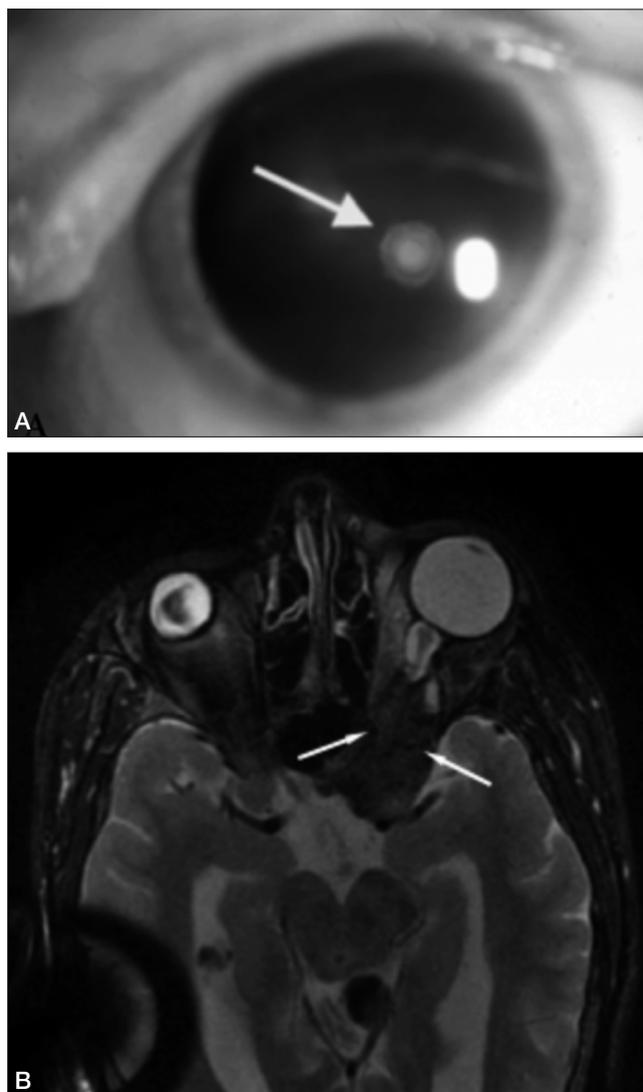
(A) Magnified view of the eye in an NF2 child showing subcapsular lens opacities (white arrow); and (B) Axial T2-weighted magnetic resonance image of the brain in a child with “congenital” NF2 showing a hypointense area (white arrows) in the intra-orbital region (“intra-orbital meningioma”).
